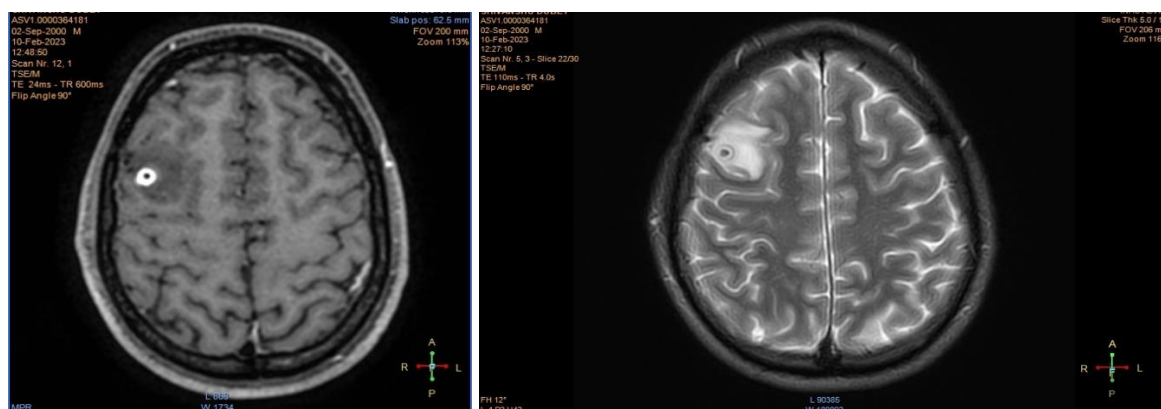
MRI in neurocysticercosis: a) Post contrast 3DT1 axial image shows ring enhancing lesion in right frontal lobe with mild perilesional edema. B) Axial T2WI shows central hypointense nodule with surrounding hyperintensity and again hypointense rim followed by perilesional edema.
